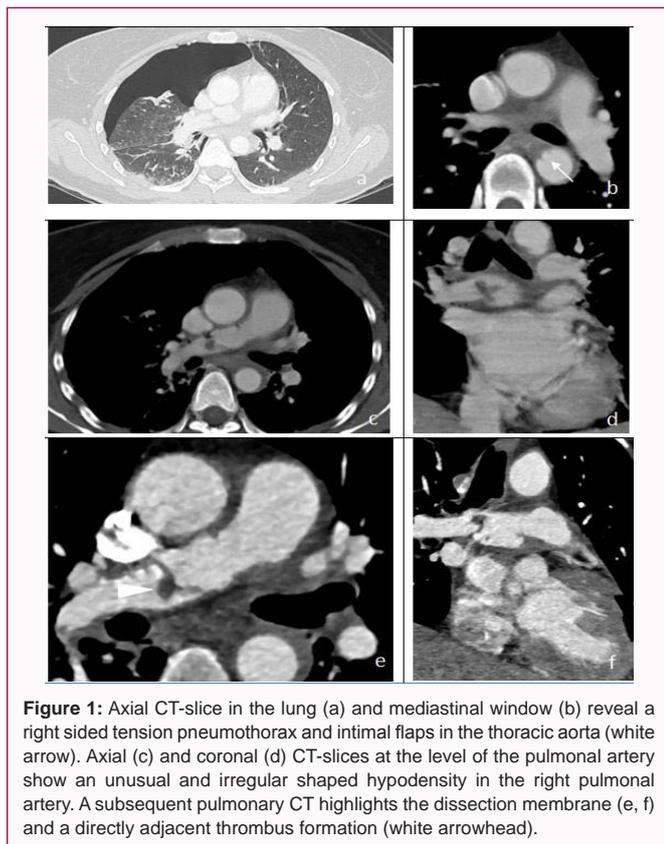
Axial CT-slice in the lung (a) and mediastinal window (b) reveal a right sided tension pneumothorax and intimal flaps in the thoracic aorta (white arrow). Axial (c) and coronal (d) CT-slices at the level of the pulmonary artery show an unusual and irregular shaped hypodensity in the right pulmonary artery. A subsequent pulmonary CT highlights the dissection membrane (e, f) and a directly adjacent thrombus formation (white arrowhead).
